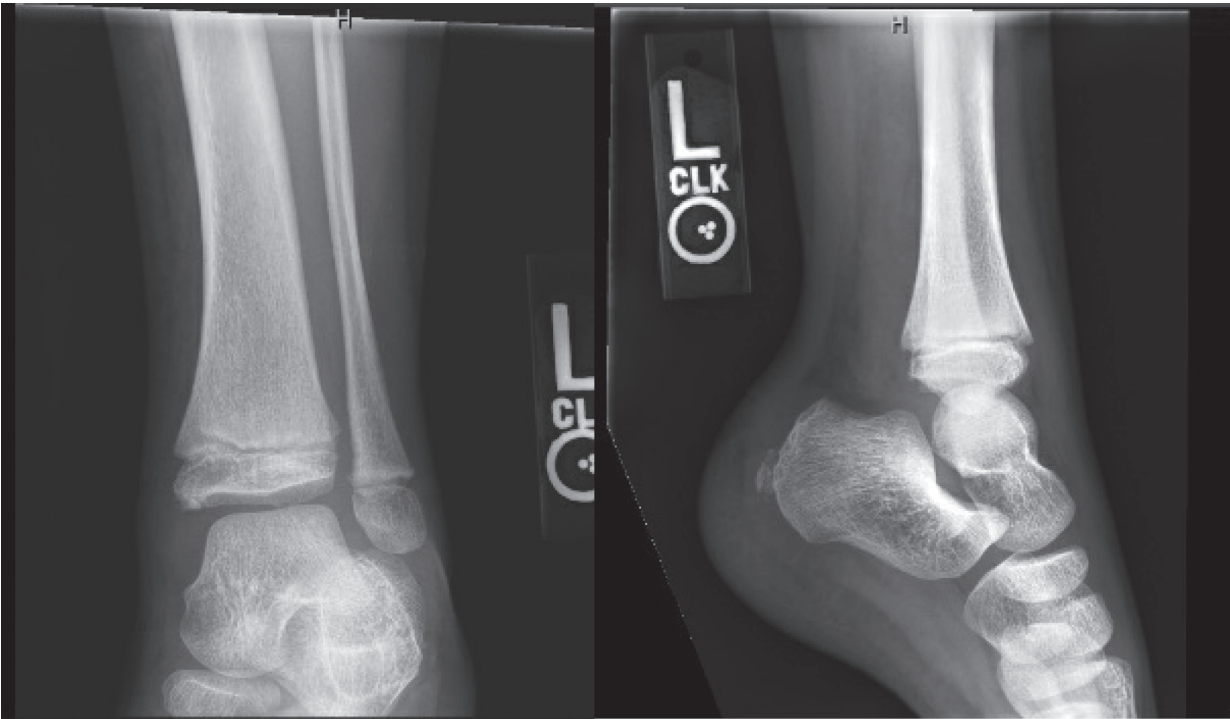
AP and Lateral radiographs of the left ankle reveal soft tissue swelling but no osseous abnormalities.
